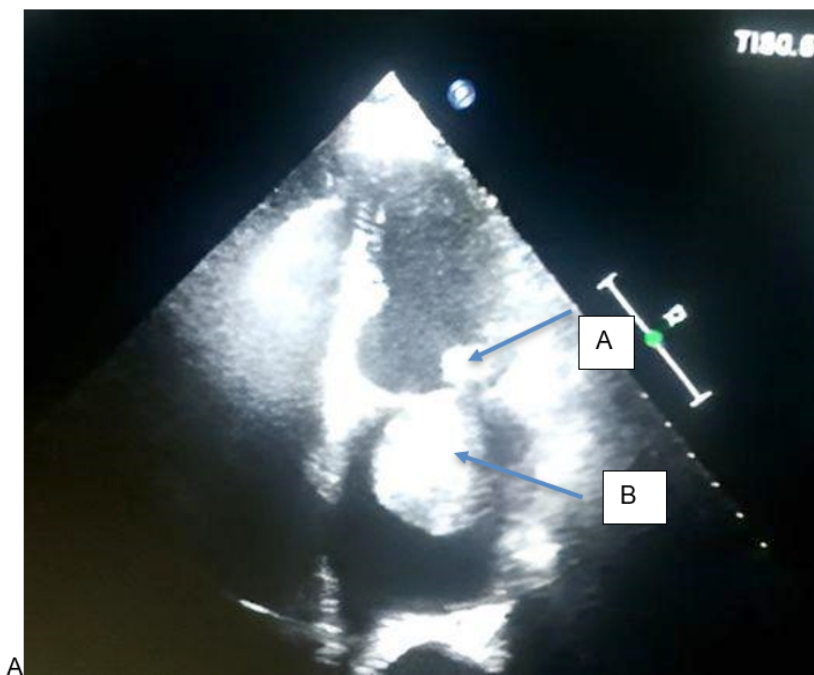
Trans thoracic Echocardiography, four chamber view showing A: Myxoma, B: Thrombus
